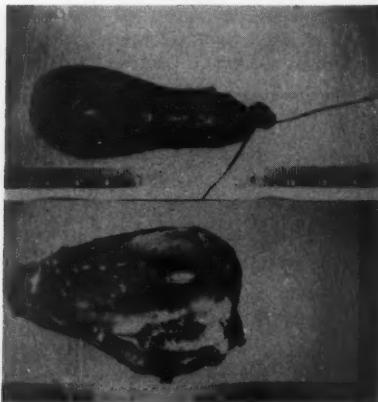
Case 2-a. The gallbladder was acutely inflamed and (b) contained, in addition to mucopurulent exudate, a small amount of milk of calcium bile accounting for the crescentic shadow seen on roentgenogram. (See fig. 2.)
